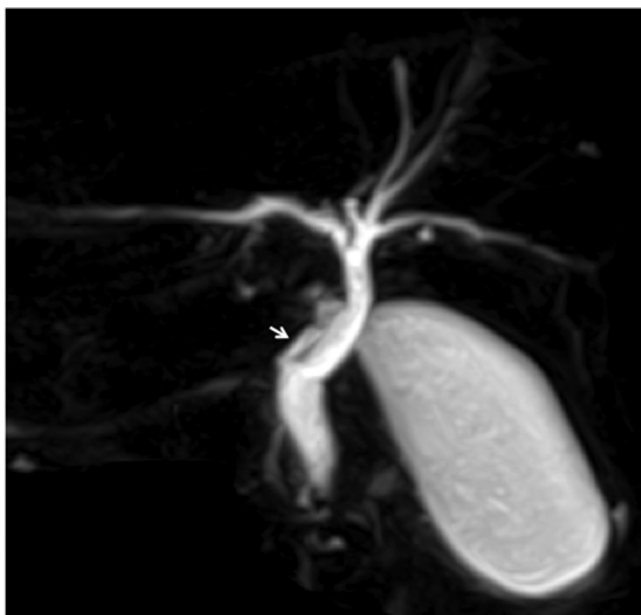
Preoperative MRI image. The cystic duct is shown (arrow). MRI reveals no anomalous bile duct.
